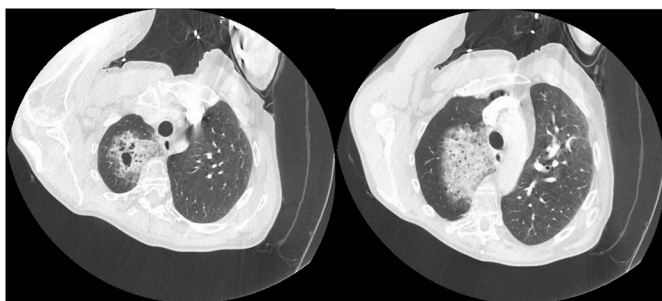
Computed tomography pulmonary angiography protocol. Cystic and cavitary changes with ground glass opacities in the right upper lobe consistent with necrotizing pneumonia and hemorrhage. The esophagus is dilated secondary to the partially obstructing esophageal cancer.
